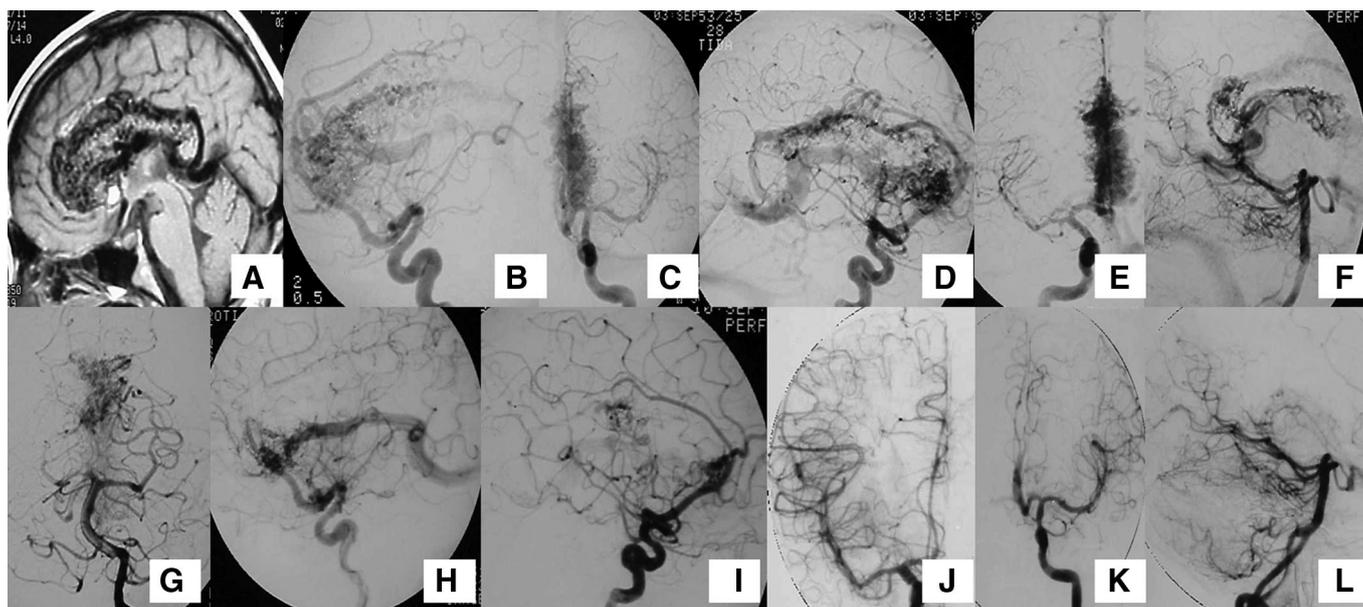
A Grade V arteriovenous malformation (AVM) located in the medial brain surface supplied by branches of both anterior and posterior cerebral arteries, treated with embolization followed by 2 surgical procedures. Sagittal magnetic resonance imaging of the AVM located in the medial brain surface in the region of the lamina terminalis, cingulate gyrus, and corpus callosum (A). Lateral (B) and anteroposterior (C) left- (D) and right- (E) side internal carotid digital angiograms showing the AVM in the medial brain surface supplied by branches of both anterior cerebral arteries. Lateral (F) and anteroposterior (G) angiograms of the posterior cerebral circulation showing the branches of the posterior cerebral arteries supplying the AVM. Left- (H) and right- (I) side internal carotid digital angiogram after embolization. Left- (J) and right- (K) side internal carotid and lateral posterior cerebral (L) angiograms after 2 surgical procedures showing complete AVM resection.
